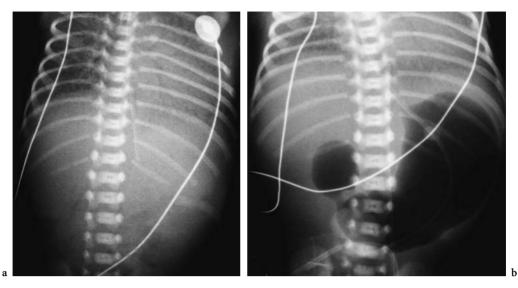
Duodenal atresia. a Plain radiograph obtained 6 h after birth shows absence of air in the gastrointestinal tract of this neonate with severe lung disease. b Radiograph made after inflation of the stomach through a nasogastric tube demonstrates complete duodenal obstruction ("double bubble" sign)
